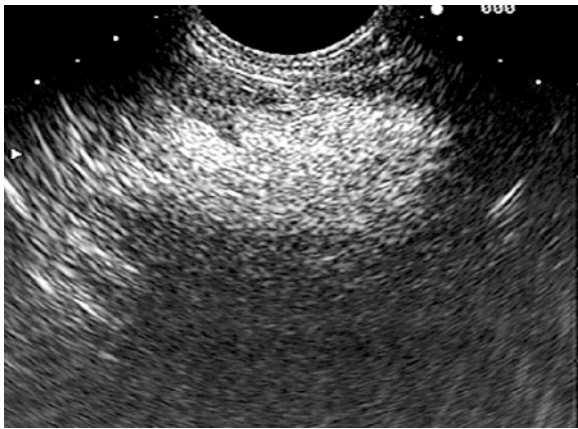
Fatty infiltration of the pancreas. The patient underwent CT scanning of the abdomen for unrelated issues, with an incidental note of a focal hypodense mass in the pancreatic head. EUS demonstrates abnormally hyperechoic tissue in the expected region of the pancreatic head which shadows and precludes visualization of deeper structures. Subsequent MRI confirmed increased fat density and the absence of a mass to correspond to the region of concern on CT.
